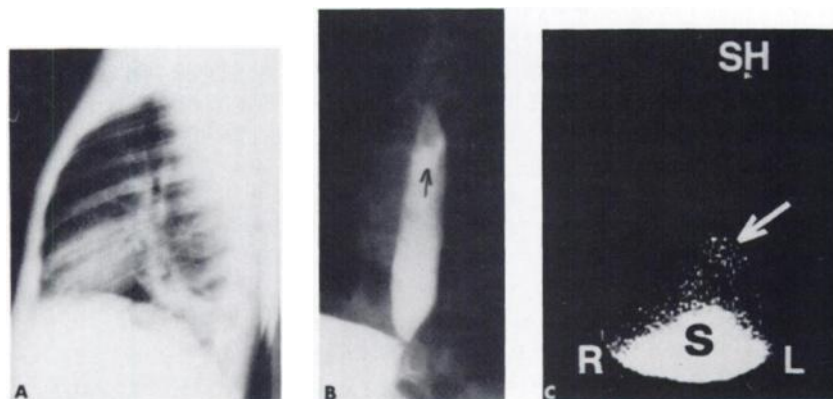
Lateral chest radiograph (A) demonstrates L. lower lobe infiltrate. Barium esophagram (B) shows moderate G-E reflux. 4-hr Tc-99m sulfur colloid image (C) shows LLL activity (arrow) (S = stomach). (Patient 20, Table 1).
